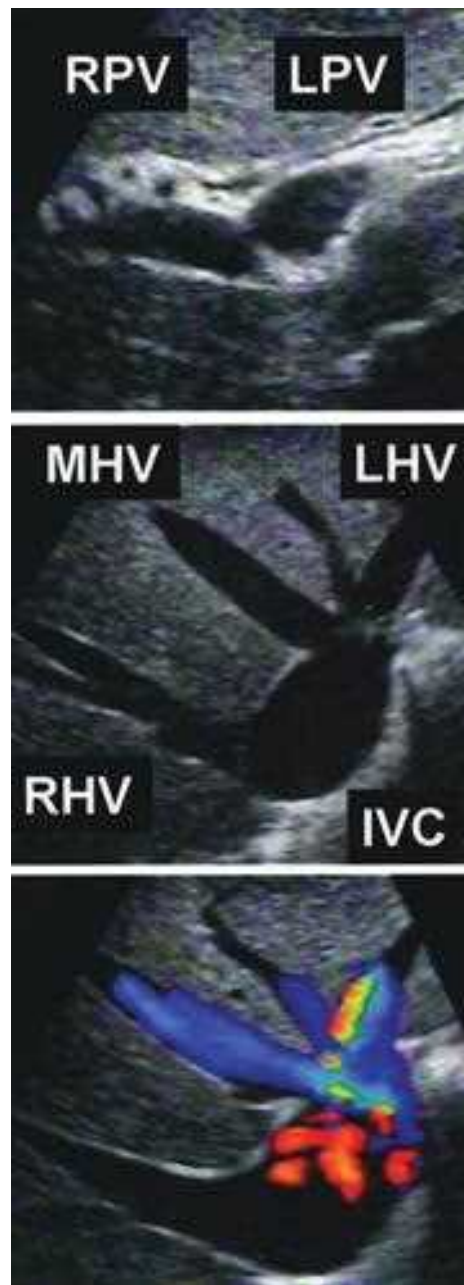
Intraoperative liver ultrasound images of the portal veins, hepatic veins, and inferior vena cava (IVC). *Upper panel* shows the portal vein bifurcation with echogenic Glissonian sheath. The confluence of the three hepatic veins (right hepatic vein [RHV], middle hepatic vein [MHV], and left hepatic vein [LHV]) and the IVC is shown in the *middle panel*. An accessory LHV is present in this patient. *Lower panel* is a color Doppler image showing flow.
